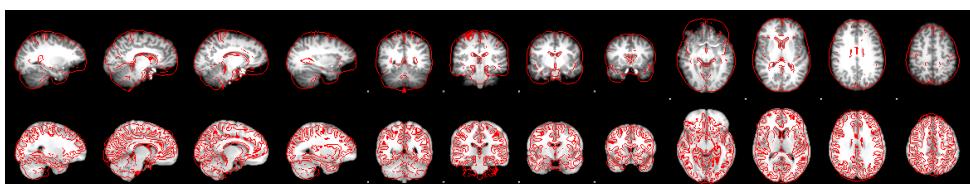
Normalization of structural MRI data onto the MNI space using full search & 3 DOF
